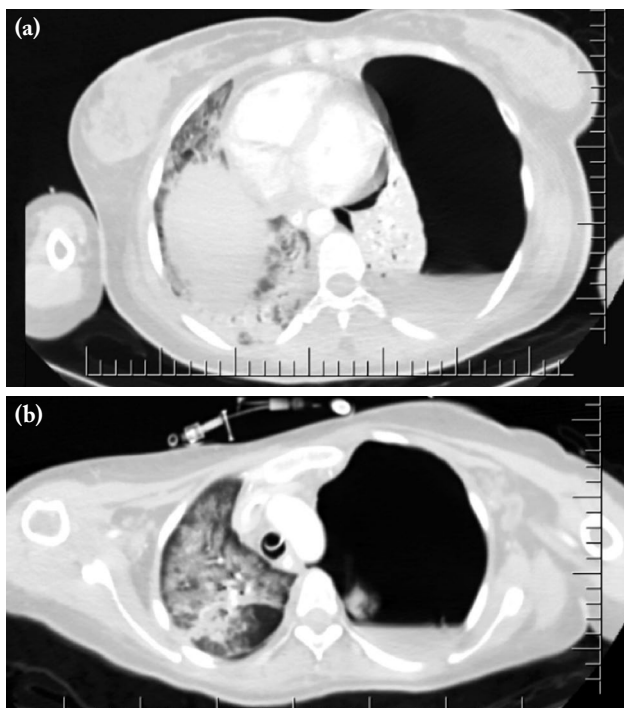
Control computed tomography scans showing no pneumomediastinum. (a) Massive pneumothorax and pleural effusion at left; (b) right-sided cardiac shift and massive pneumothorax at left.
